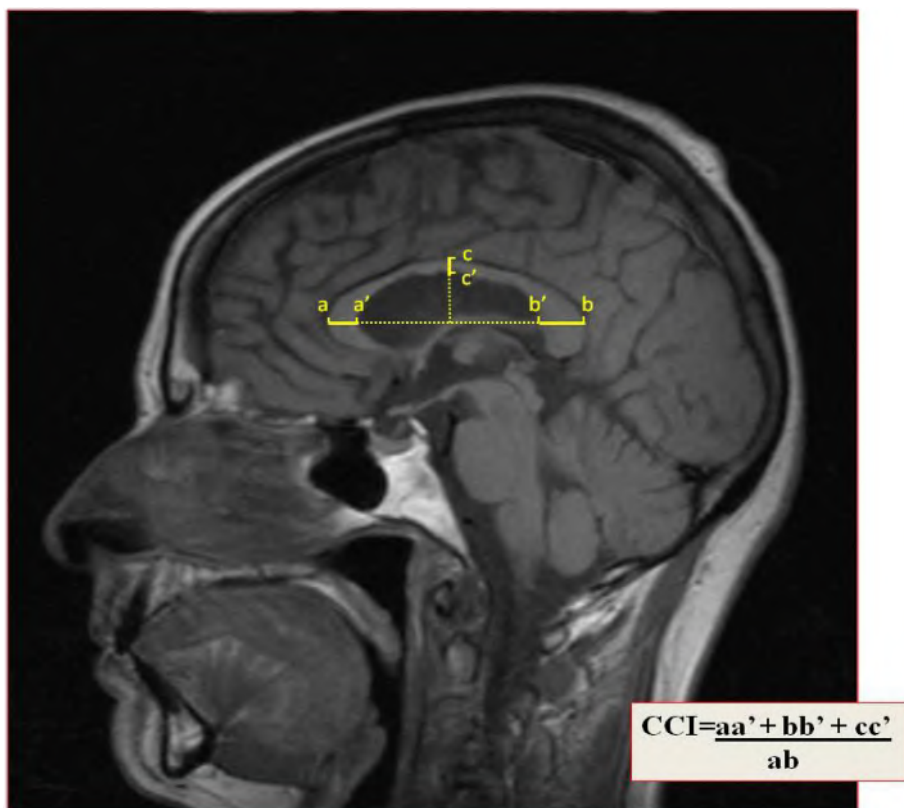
The corpus callosum index is a simple and feasible tool obtained from two-dimensional measurement of the corpus callosum using an orthogonal semi-automated linear model, applied to a conventional mid-sagittal T1-Weighted Magnetic Resonance Imaging sequence.
